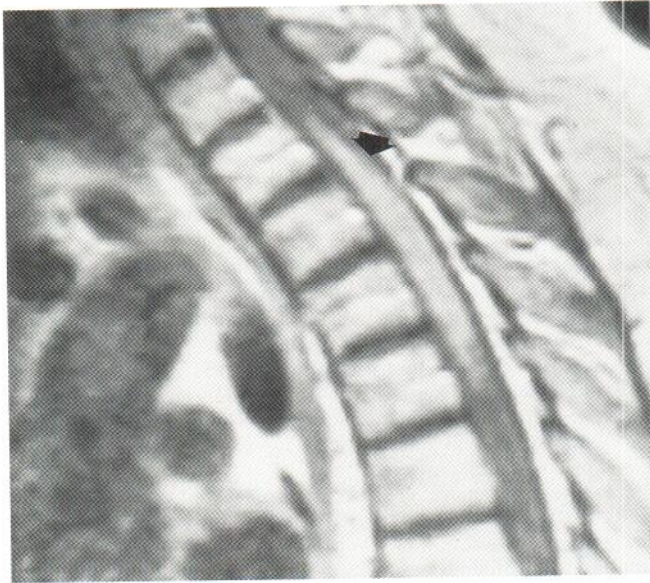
Magnetic resonance image of the thoracic spine, sagittal section enhanced with gadolinium, revealing a hyperdense intramedullary lesion (arrow).
